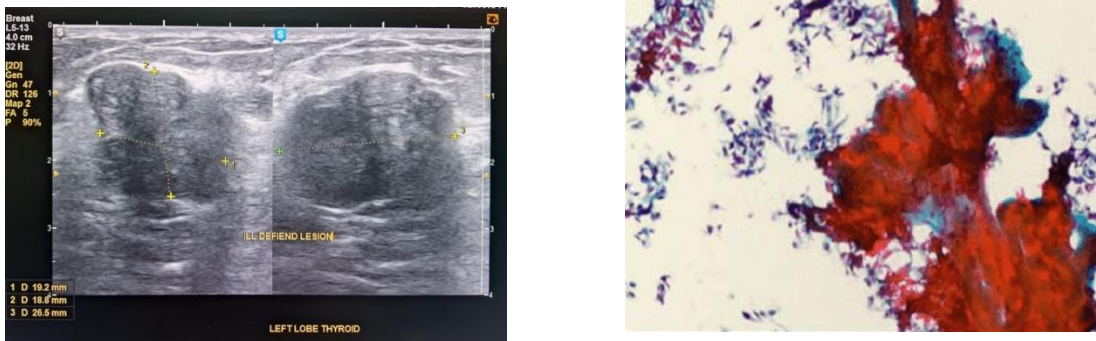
Papillary carcinoma of thyroid:A37-year-old female with palpable neck swelling. On USG, a heterogeneously hypo echoic, ill defined, lobulated lesion with micro-calcifications and intense vascularity on colour Doppler is seen in left lobe of thyroid. Thyroid FNAC of the lesion showed hyper-cellular neoplastic cells in papillary form arranged as sheets with nuclear pseudo inclusions.
